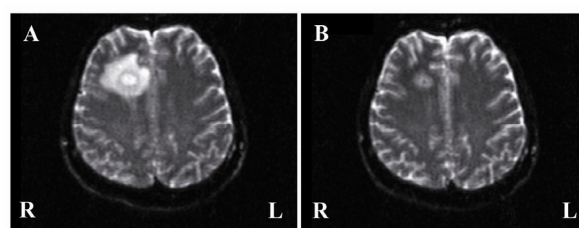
Magnetic resonance images of the brain abscess. Both images are taken by diffusion weighed imaging. A: Axial image at 22nd week of pregnancy shows the large right frontal abscess with severe edema. B: Axial image at 28th week of pregnancy shows no enlargement of the abscess and disappearance of the surrounding edema
